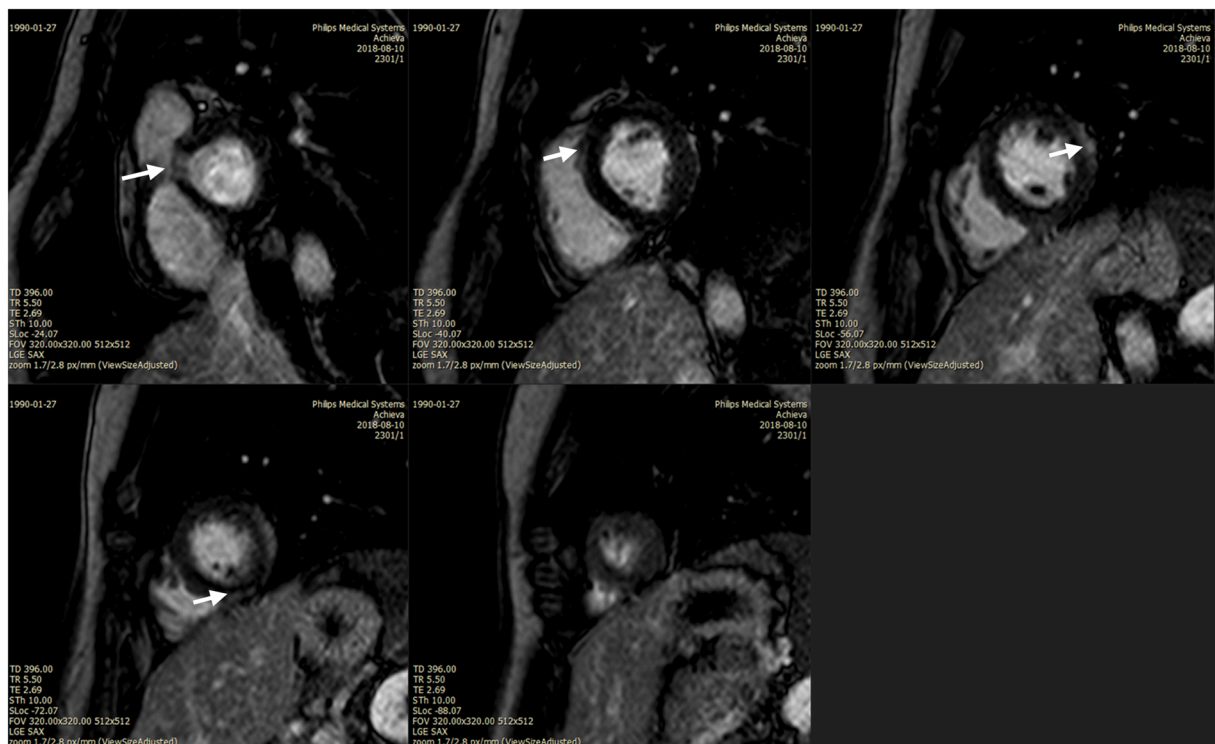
Cardiac MRI showed myocardial necrosis in multiple sites (white arrows).
